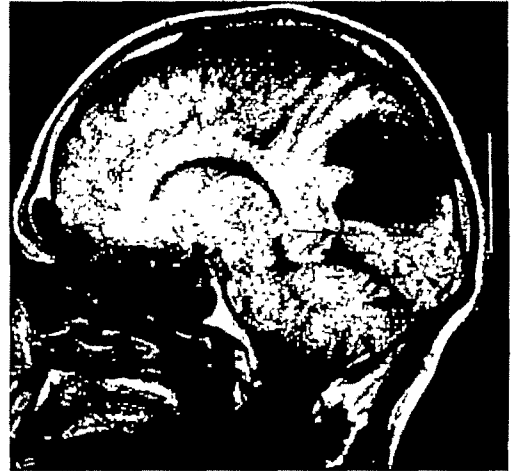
Sagittal magnetic resonance image of the right occipital lobe in *Case 2* (TR = 600 ms, TE = 20 ms). A large tumour is present in parieto-occipital cortex. The calcarine sulcus (between arrows) and occipital pole are preserved. Scale = 5 cm.
